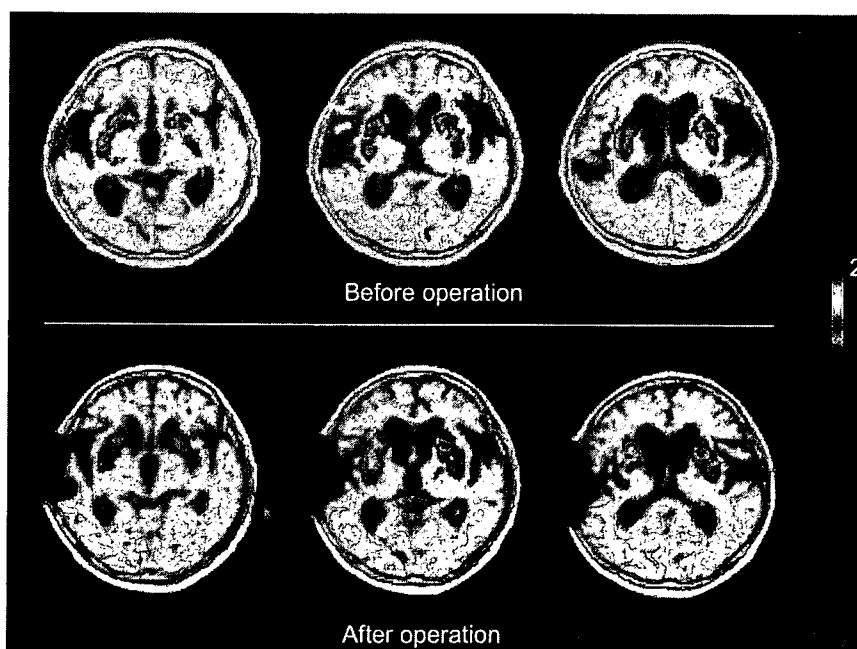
PET/MRI fusion parametric images of quantitative ^{11}C -raclopride BP in an iNPH patient before and after shunting. Color bar denotes BP for ^{11}C -raclopride (0–2).
